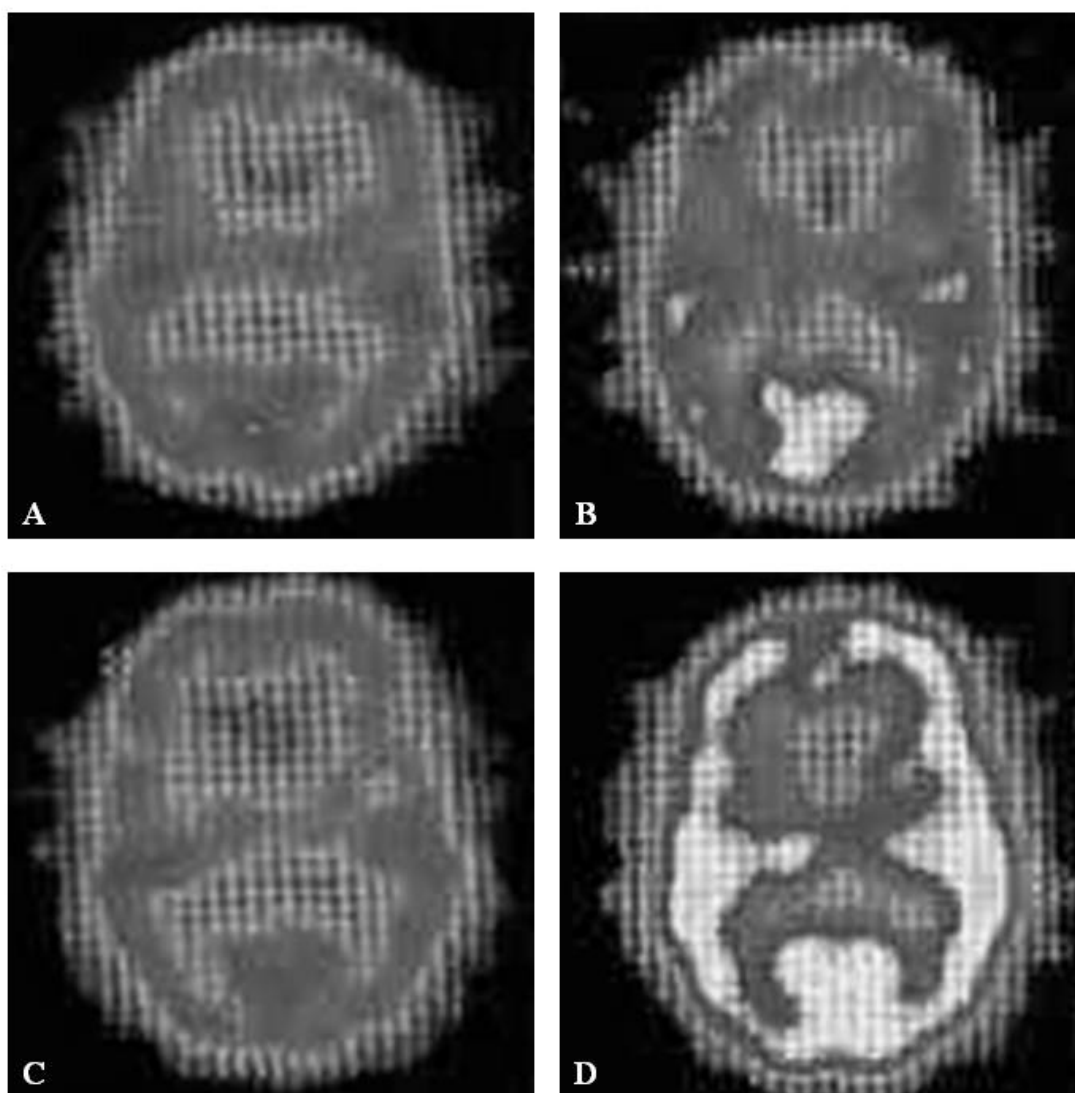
Preoperative IMP SPECT showing a decreased cerebrovascular reactivity to acetazolamide in bilateral cerebral hemispheres (A: basal study, B: acetazolamide study). IMP SPECT obtained one month after the surgery demonstrating a normalized cerebrovascular reserve in both cerebral hemispheres (C: basal study, D: acetazolamide study).
